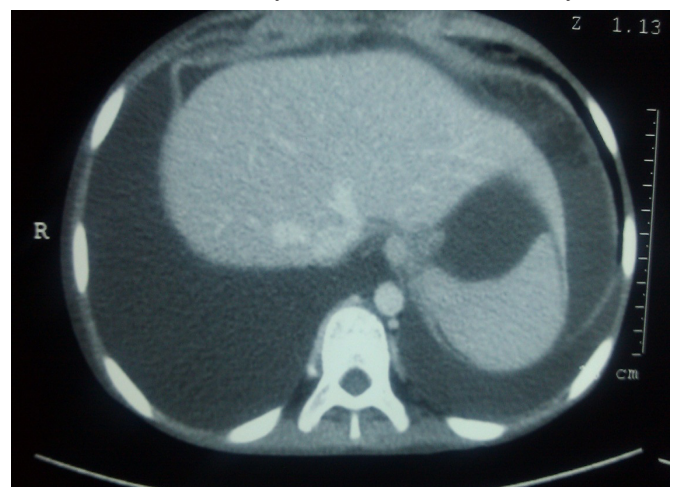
Contrast enhanced CT scan abdomen showing free fluid in the abdomen
